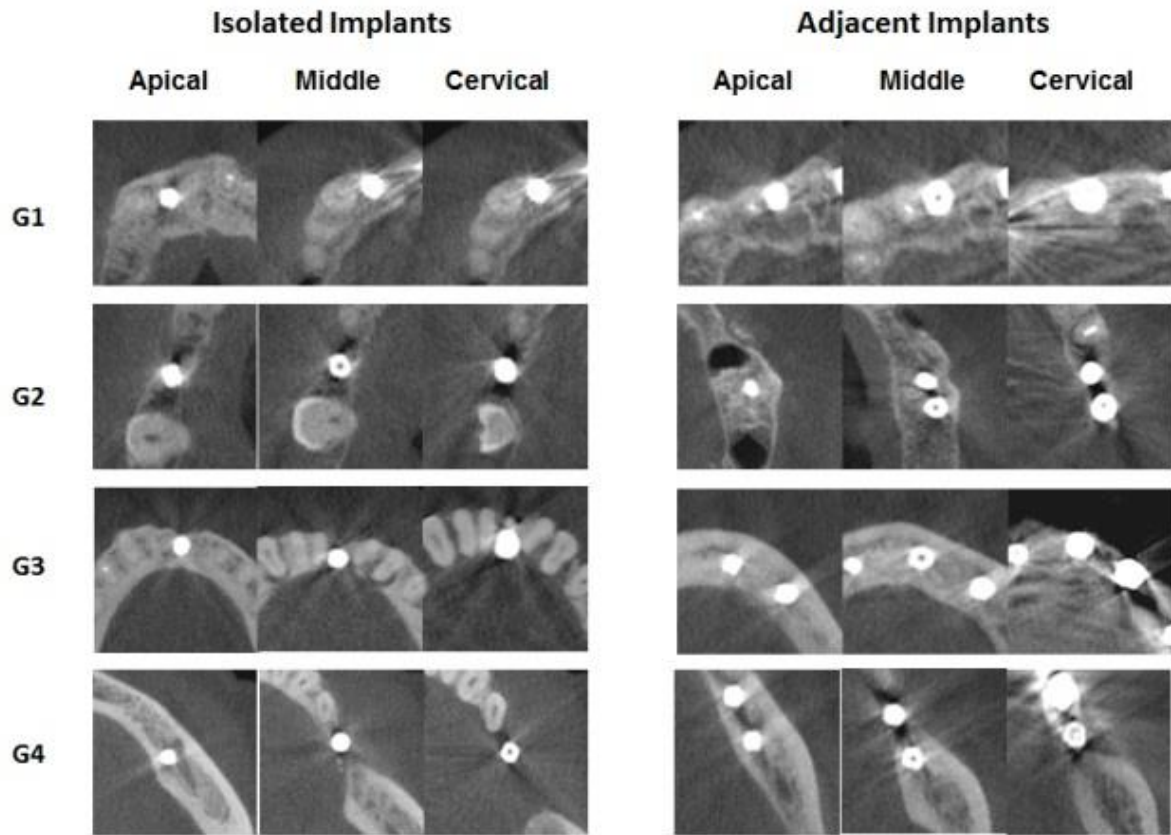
Examples of metal artifacts in CBCT images of dental implants in axial slices.
